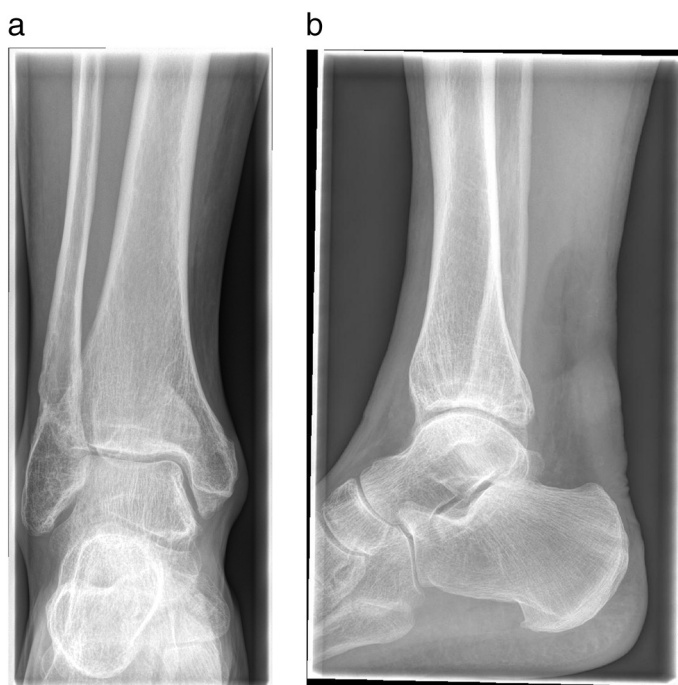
a: Anteroposterior radiograph of the right ankle dated 22 March 2017.
